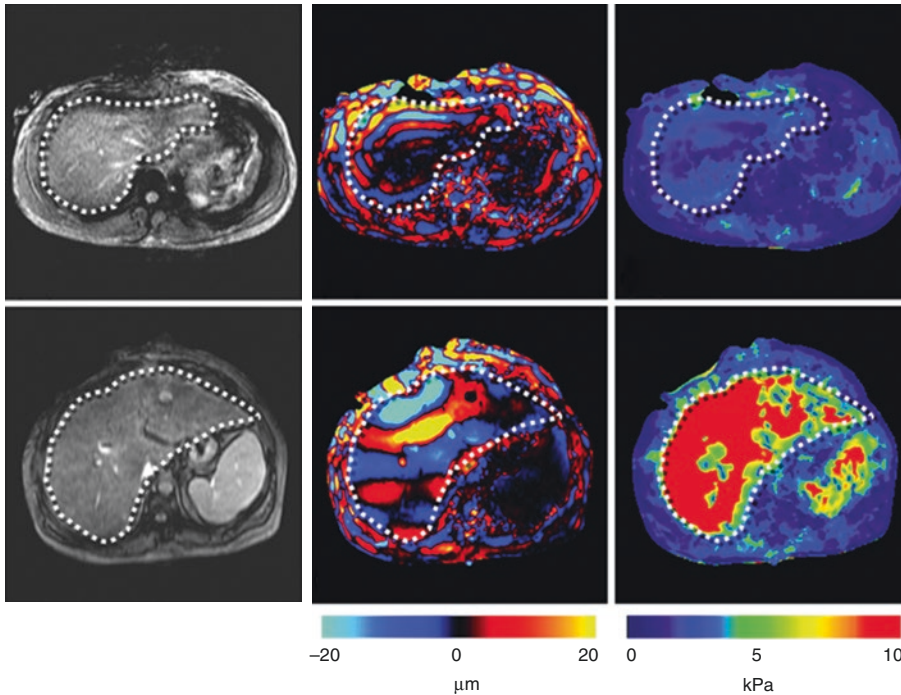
Magnetic resonance elastography data from a patient with normal liver (a–c) and a patient with cirrhotic liver (d–f). Typical magnitude MR images show little difference between healthy and cirrhotic liver (a, d). Images of acoustic shear wave propagation reveal a substantially
